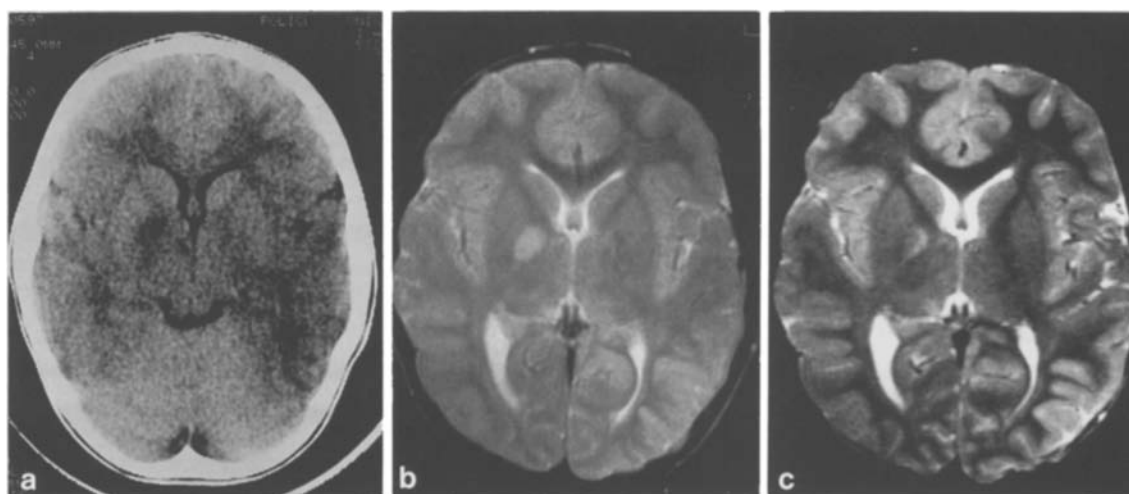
a Brain computed tomographic (CT) scan at the age of 5 years 2 months: an area of hypodensity is present in the right globus pallidus and internal capsule. b Brain magnetic resonance image (MRI) at the age of 8 years: an area of increased signal is
